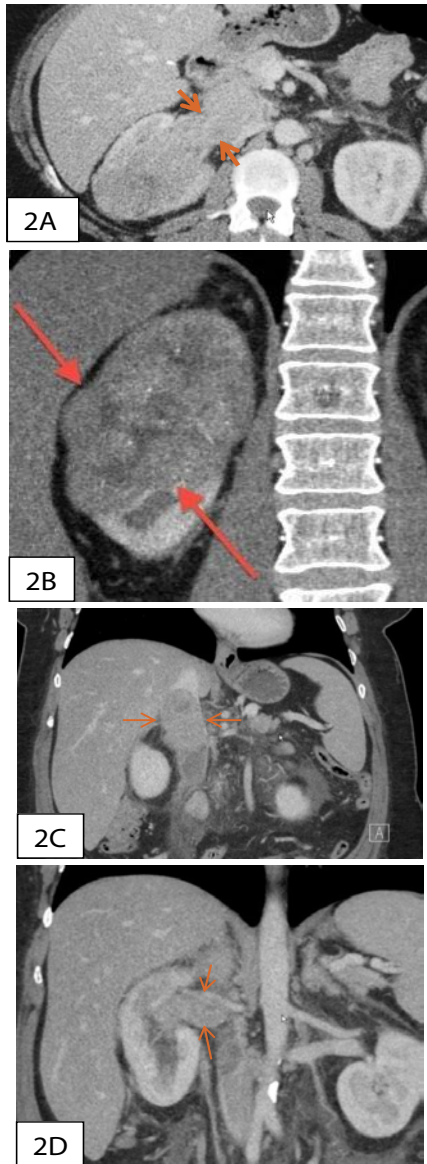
rPNET arising from the right kidney in a 46-year-old woman. Contrast enhanced axial (2A) and coronal (2B, 2C & 2D) CT images demonstrate a large diffusely infiltrating mass in upper pole of right kidney replacing the normal renal parenchyma showing moderate grade enhancement. Please note that the shape and contour of the kidney is well maintained and the mass is diffusely infiltrating. The mass is extending into the IVC and right renal vein which are expanded and completely filled with enhancing tumor thrombus (red arrows).
